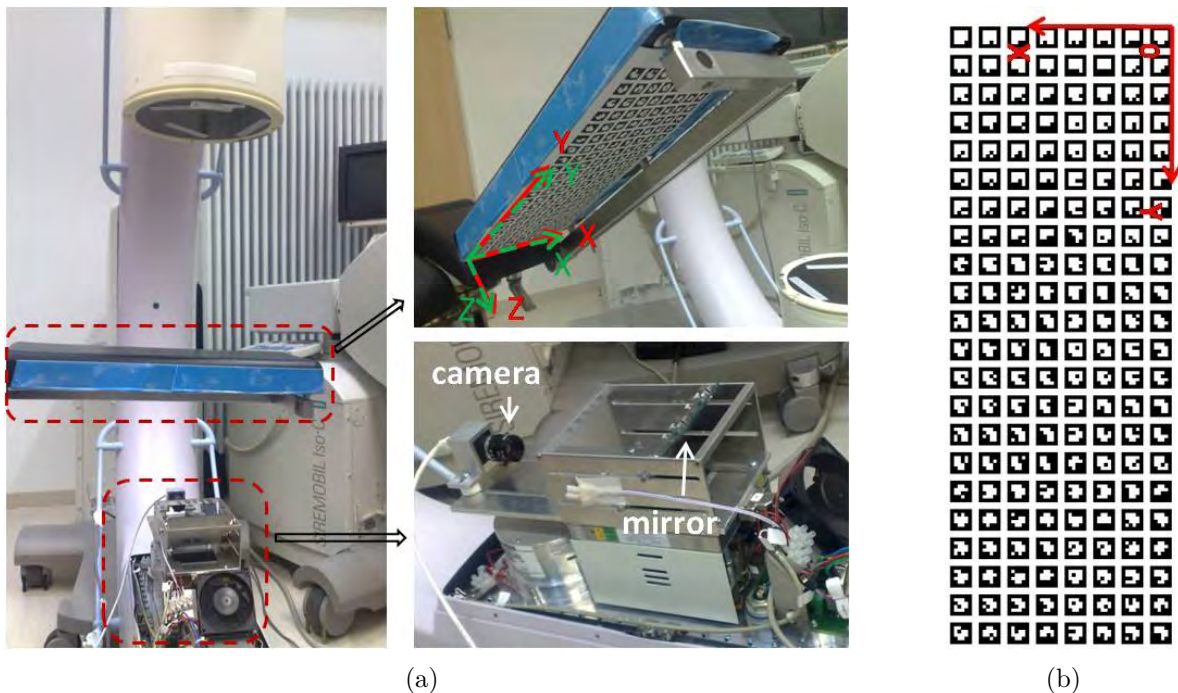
(a) The left image shows the setup for X-ray image stitching, in which the camera can see the marker pattern attached to the back of the operating table. The right top image shows the attachment of the marker pattern under the table and both marker and table coordinate systems. The right bottom image shows our custom made camera and mirror construction; (b) Our planar square marker pattern and its coordinate system. The edge length of a square marker is 16.5mm, the distance between two markers is 5.5mm.
